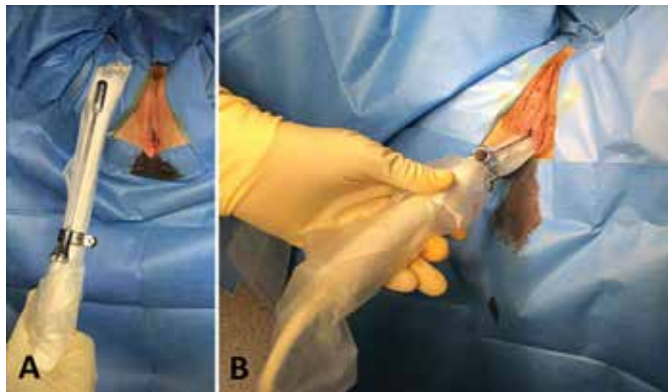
Ultrasound scanning to identify the collection and prepare its puncture. The endovaginal ultrasound probe is covered with a sterile probe cover and gel and equipped with a guide for follicular puncture (A). Ultrasound scanning permits to identify the collection to be evacuated and located immediately in contact with the vaginal wall (B).
